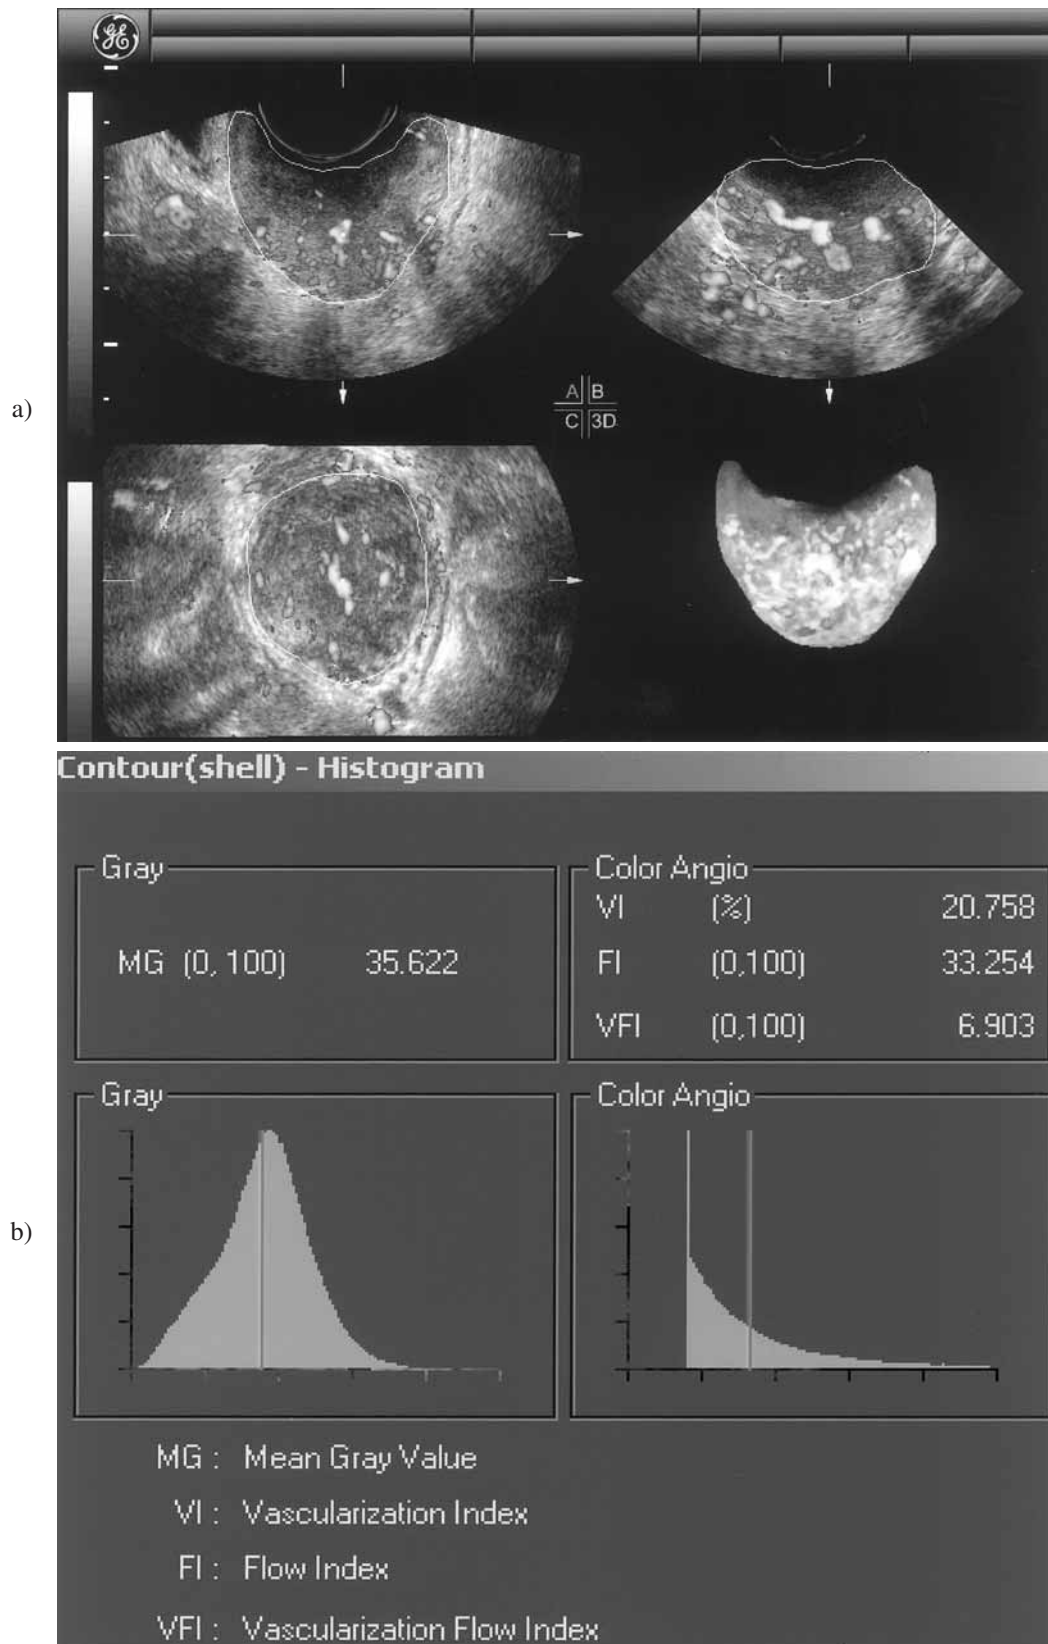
An example of invasive cervical cancer analyzed by three-dimensional (3D) color power Doppler ultrasound angiography: a) longitudinal view, upper left; frontal view, lower left; transverse view, upper right; reconstructed tumor mass, lower right; b) VOCAL histogram analysis of 3D power Doppler sonography in a cervical cancer patient.
